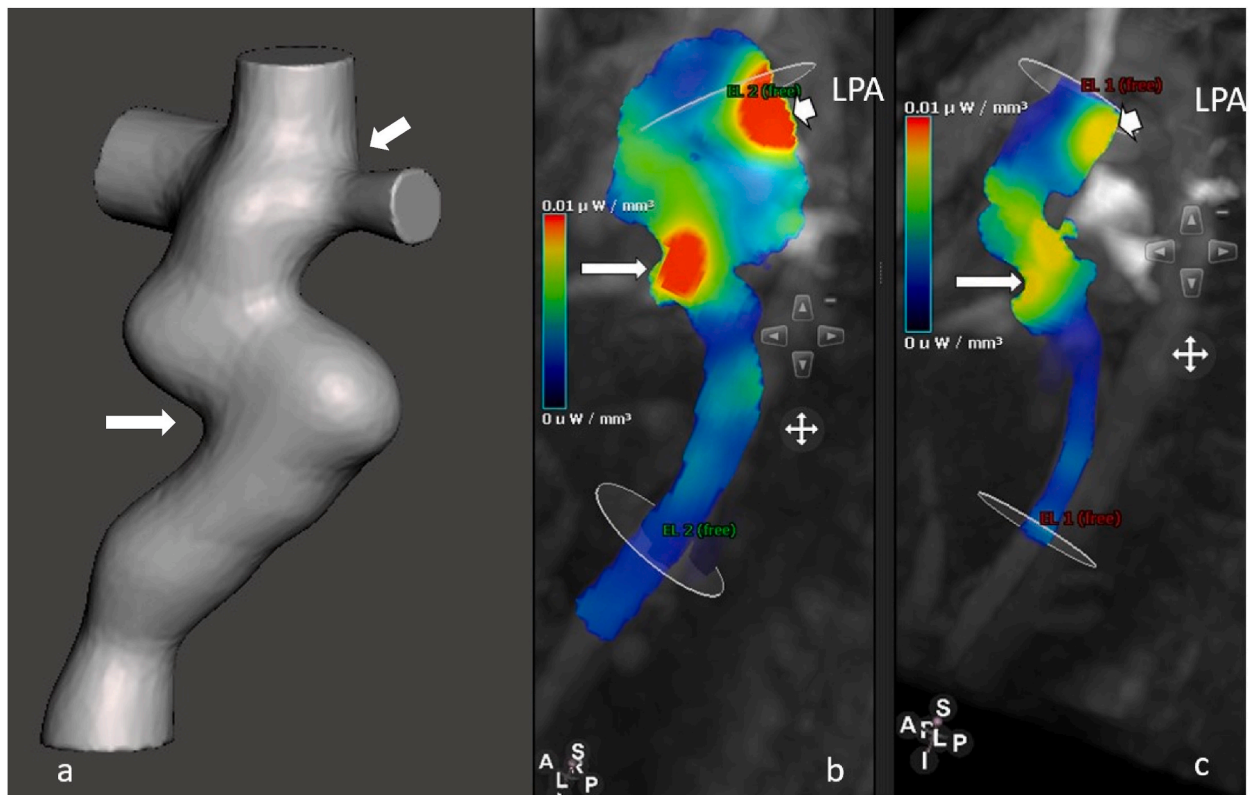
Pre- and post-intervention 4D flow MRI viscous energy loss maps are compared at the same region of interest (ROI). Figure (a) Anatomical segmentation of the geometry before stent implantation. The arrows show the IVC-Fontan tube connection and LPA (b) The preoperative image indicates higher viscous energy loss levels at the anastomoses site of the IVC-conduit as well as at the location of the stent at the left pulmonary artery. Indicated by white arrows. (c) The corresponding postoperative image shows the removal of the pre-interventional high viscous energy loss sources after re-stenting the left pulmonary artery and balloon dilatation of anastomoses site of IVC-Conduit. Indicated by white arrows.
